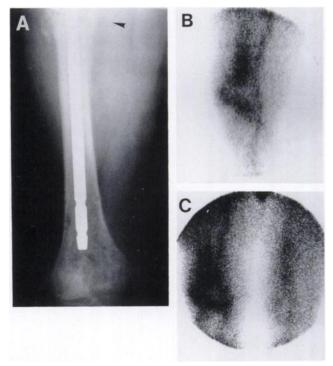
Patient 8, a 48-yr-old male. Recurrent infections of traumatic right femoral fracture, now with fever and localized pain. Indium-111-IgG and 3PBS consistent with infection at distal intramedullary rod. Patient responded well to antibiotic treatment with negative intraoperative cultures when the rod was removed 1 mo later. (A) Plain radiograph with probable proximal nonunion (arrowhead). (B) Indium-111-IgG 24-hr image. (C) 3PBS blood-pool image.
